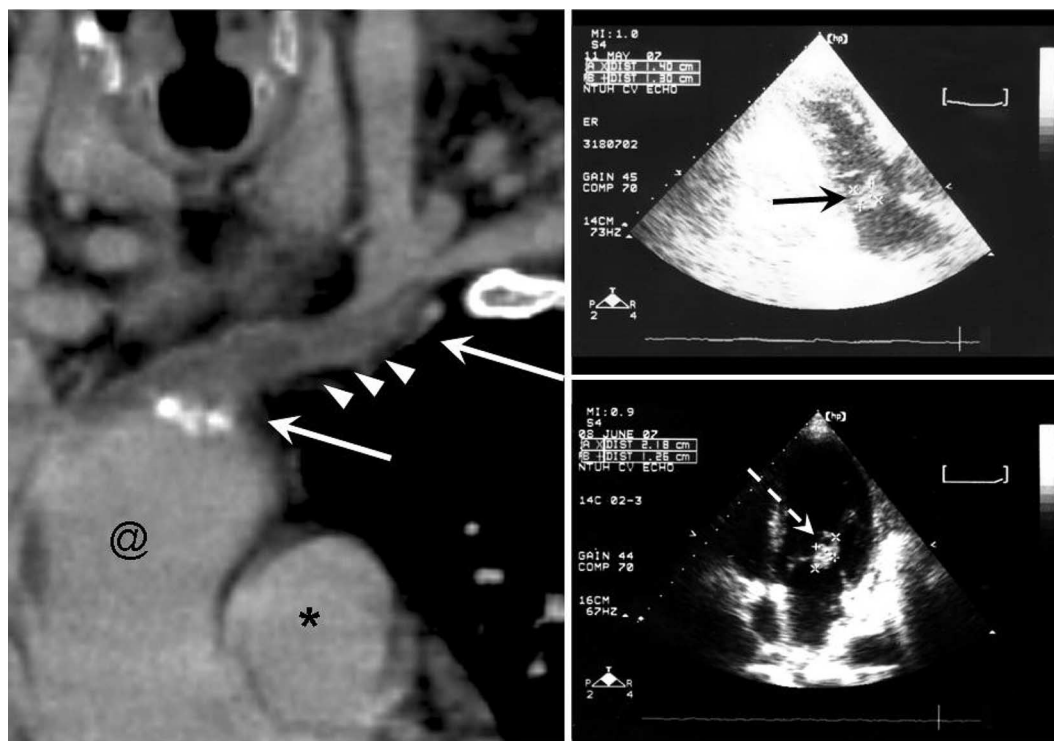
(Left) Computed tomographic image generated by curved multiplanar reconstruction showing thrombosis over the left brachiocephalic vein. Arrows, thrombus; arrowheads, peripheral edema of vascular wall; @, superior vena cava; *, aorta. (Right) Transthoracic echocardiographic images. The vegetation sizes were 1.40 cm by 1.30 cm on hospital day 44, when infective endocarditis was first diagnosed (upper right, black arrow), and 2.18 cm by 1.26 cm on hospital day 72, when the blood culture became negative (lower right, white arrow).
